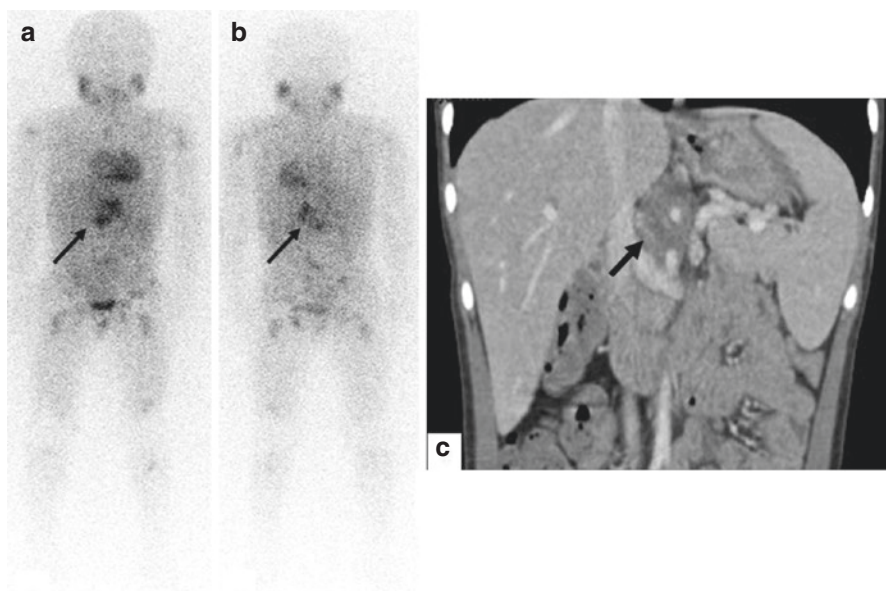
A 6-year-old male affected by stage 4 NB. ¹²³I-MIBG scan at the time of first staging (a, b) identified primary tumor (arrows), well visualized by CT (coronal view, c), and bone-bone marrow metastases
